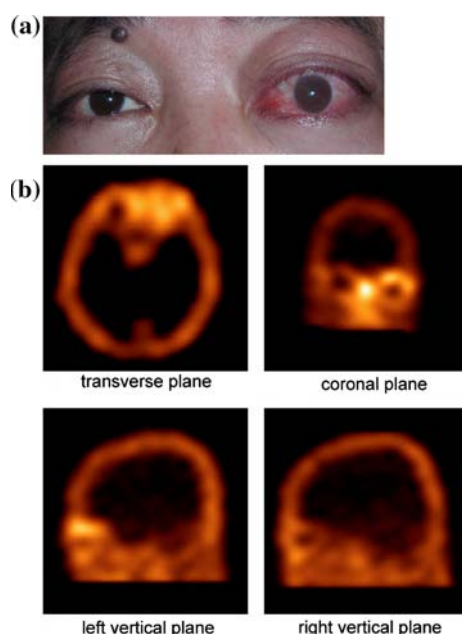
The GO patient complained left eye pain, redness, swelling, and impairment. (a) The SPECT images of the case in the transverse, coronal, and vertical planes. The images showed markedly elevated ^{99m}Tc -HYNIC-TOC uptake in left orbit compared with right orbit (b) Note that the apparent orbit findings of inflammation (such as pain, redness, swelling, impairment) are synonymous with the increased ^{99m}Tc -HYNIC-TOC uptake in the 4-h scintigraphy
